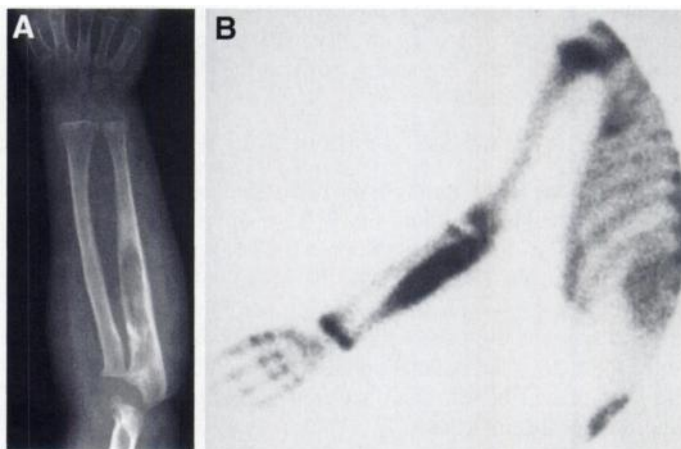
Two-year-old boy with biopsy-proven lesion in the left ulna. (A) Radiograph of left forearm shows a lytic destructive lesion in the metaphysis and proximal diaphysis of the ulna. (B) Bone scintigraphy of left upper extremity shows avid radiotracer uptake in the mid and proximal ulna.
